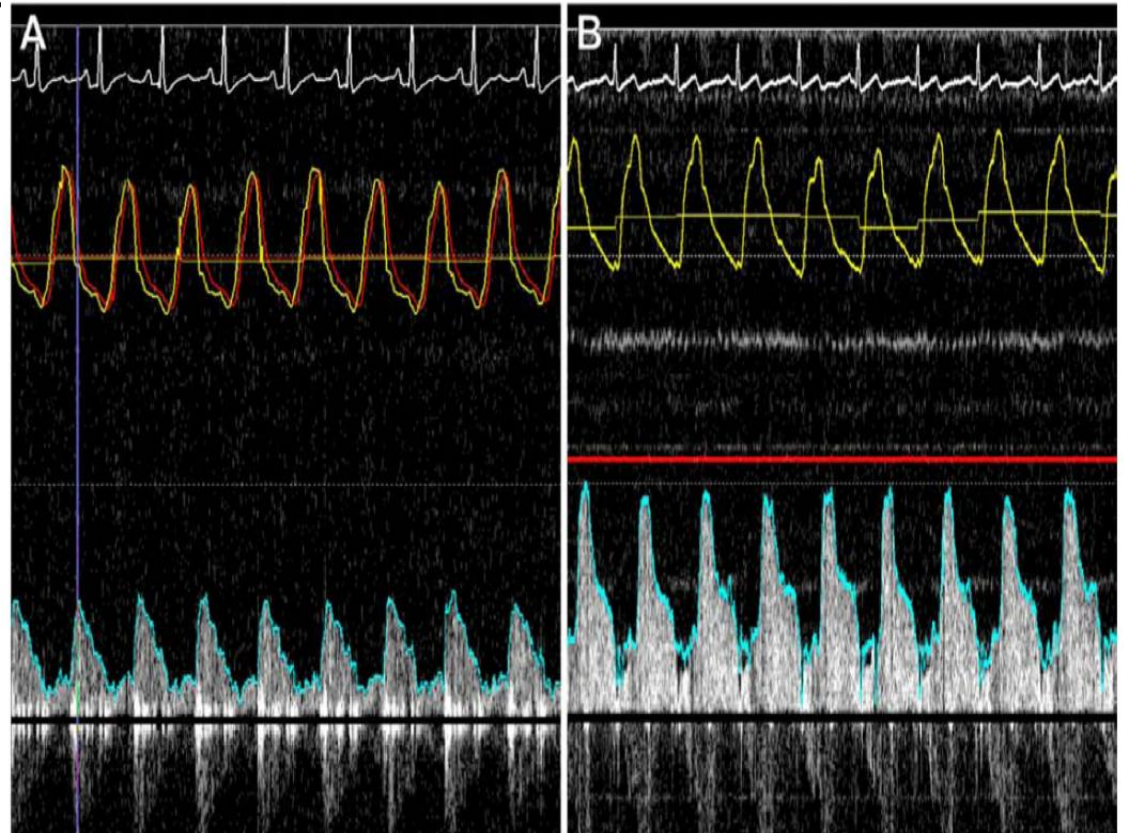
Finger Tip Phenomenon During Intracoronary Doppler Measurements
